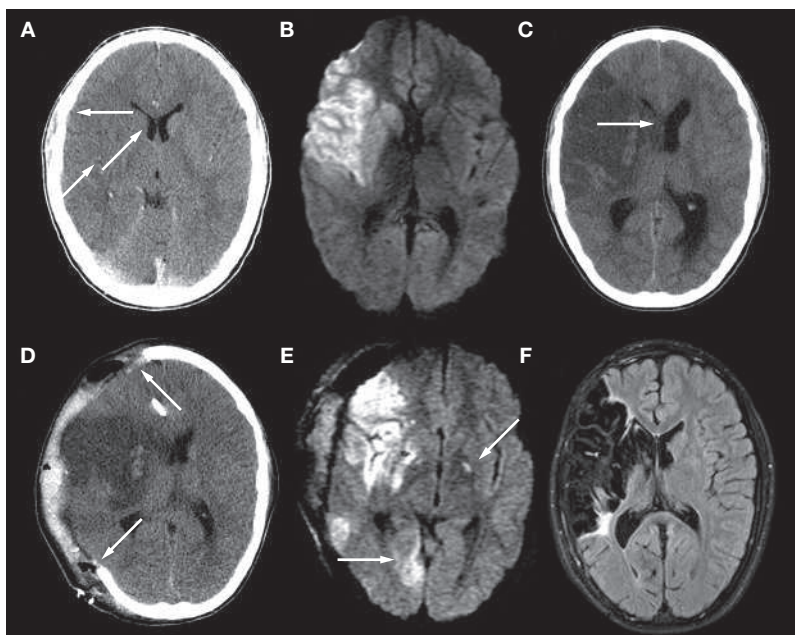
Evolution of ischemic stroke complicating cardiac catheterization in a boy with aortic hypoplasia. (A) A CT head scan done 90 min from onset of symptoms demonstrates subtle loss of signal in the caudate and lentiform nuclei and loss of cortical grey–white differentiation. (B) Diffusion-weighted MRI 60 min later confirms infarction in the right middle cerebral artery territory. (C) A head CT at 36 h showing marked cerebral edema with midline shift (arrow) requiring (D) decompressive craniotomy. (E) Repeat diffusion-weighted MRI at 72 h shows new infarcts including the left globus pallidus and right occipital lobes (arrows). (F) Fluid-Attenuated Inversion Recovery MRI 3 years later shows encephalomalacia and gliosis of the infarcted areas.
